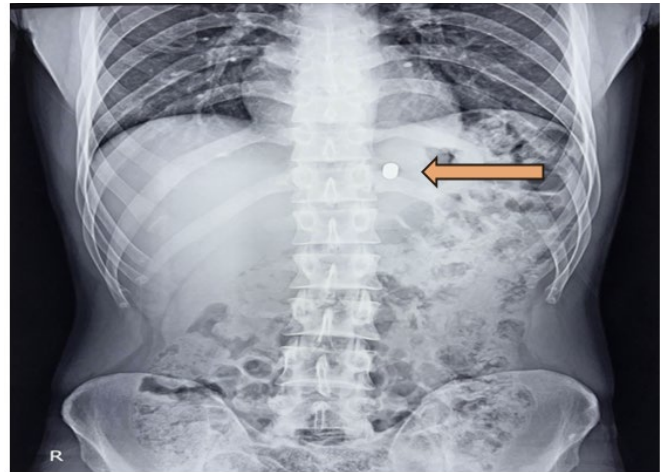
X-ray Abdomen AP view of the patient suggestive of metallic density foreign body
